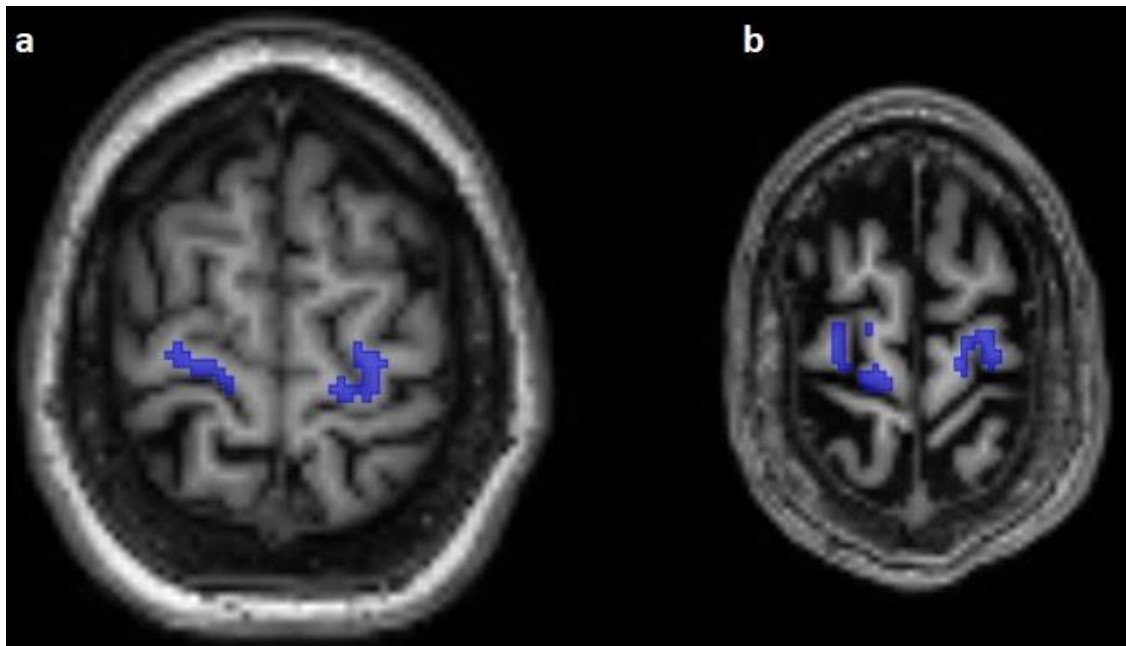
The predicted course of the corticospinal pathway (blue) in the subcortical white matter of the precentral gyrus on axial T1-weighted images. Note the absence of predicted fibers in the subarachnoid space as well as the fibers following the pattern of the minor gyri (a,b).
